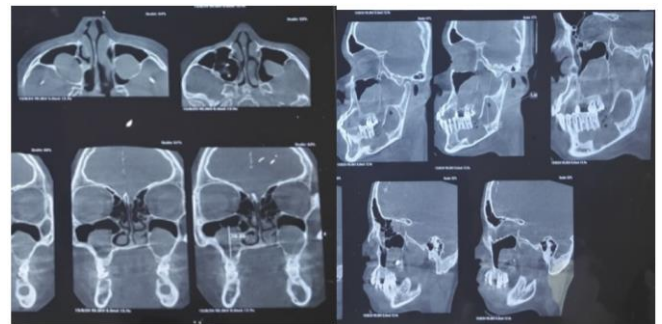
CBCT demonstrating bilateral uniformly hypodense lesions with superior displacement of floor of maxillary sinus and a well-defined radiolucent lesion with incomplete septae involving the left body-ramus region
